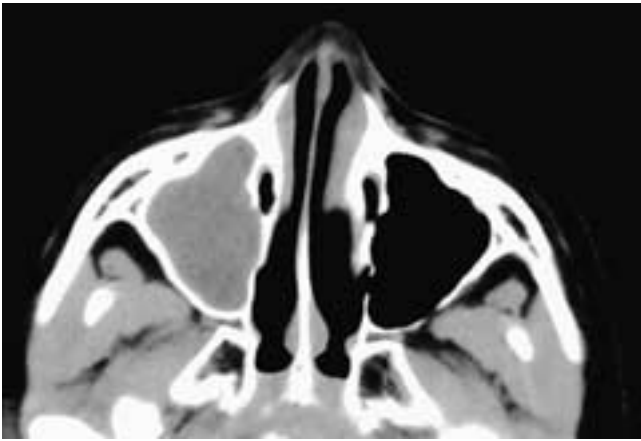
Axial CT scan shows an opacified right maxillary sinus. The attenuation of the material is approximately that of water. The sinus cavity is normal in size. This is an obstructed sinus, not a mucocoele. In a mucocoele, the sinus cavity must be enlarged.
